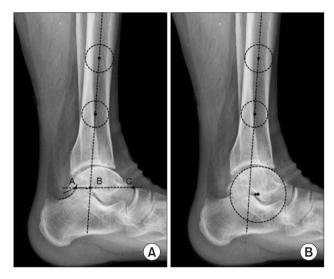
(A) Radiographic measurement of tibial axis-to-talus ratio (AB / AC \times 100). Posterior talar point (point A) is identified as the intersection between the contours of the posterior subtalar articular surface and the posterosuperior calcaneal cortex. Talar reference line is a line drawn through point A, parallel to the floor. Anterior talar point (point C) is the most anterior aspect of the talus. The tibia mid-diaphyseal axis is a longitudinal mid-bisecting line of the distal tibial shaft determined at 5 and 10 cm above the ankle. The intersection of the tibia mid-diaphyseal axis with the talar reference line is point B. (B) Radiographic measurement of lateral talar station (LTS). A circle was made fitting the talar dome, and the center of its rotation was measured perpendicular to the tibia mid-diaphyseal axis. This distance was defined as the LTS.
